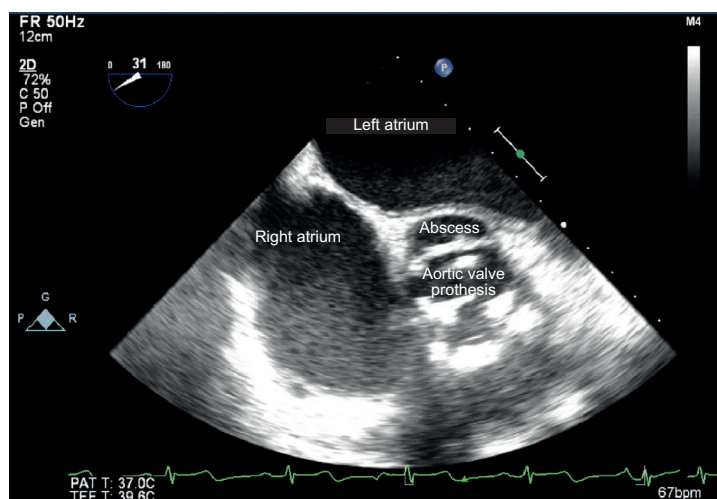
Two-dimensional transesophageal echocardiogram showing aortic prosthesis with abscess at the mitroaortic junction.
